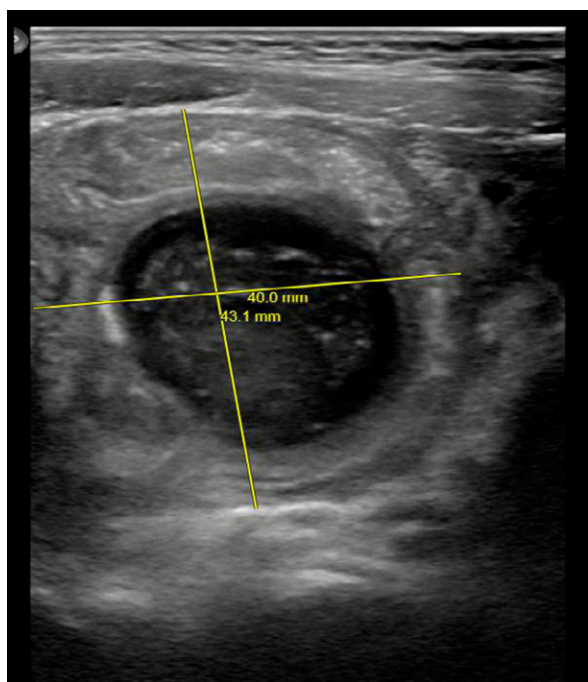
Abdominal ultrasonographic image, limited.
